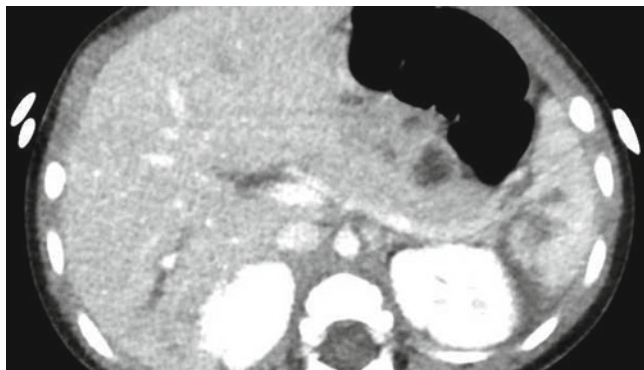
Liver and spleen lacerations in a 3-year-old with nonlocalized, mild abdominal pain and no history of trauma provided; the patient had elevated liver transaminases (ALT 320; AST 196), which prompted this abdominal CT study
